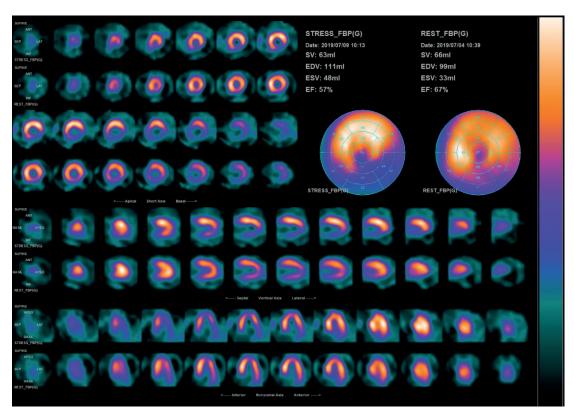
Patient 1 myocardial perfusion after ESMR therapy measured using SPECT scan.
